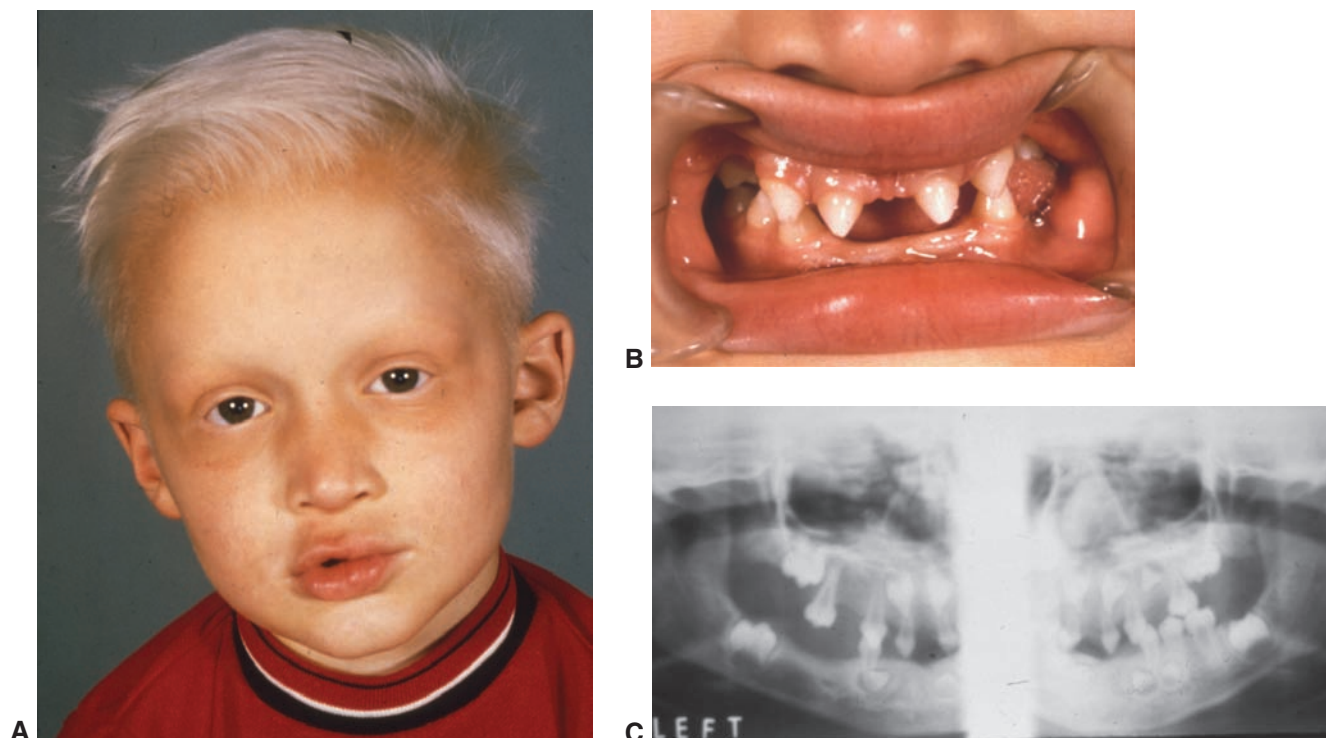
Ectodermal dysplasia. A. Young male patient shows characteristic facial appearance, with sparse fine blond hair, absence of eyebrows and eyelashes, and large lips. (Photograph courtesy of Dr. Robert Actenberg.) B. Intraoral clinical appearance of the same patient. Note multiple missing teeth. The anterior teeth have a cone-shaped crown morphology that is also commonly present in these patients. (Photograph courtesy of Dr. Robert Actenberg.) C. Panoramic radiograph of the same patient reveals an extensive number of congenitally missing teeth. (Photograph courtesy of Dr. Robert Actenberg.)
